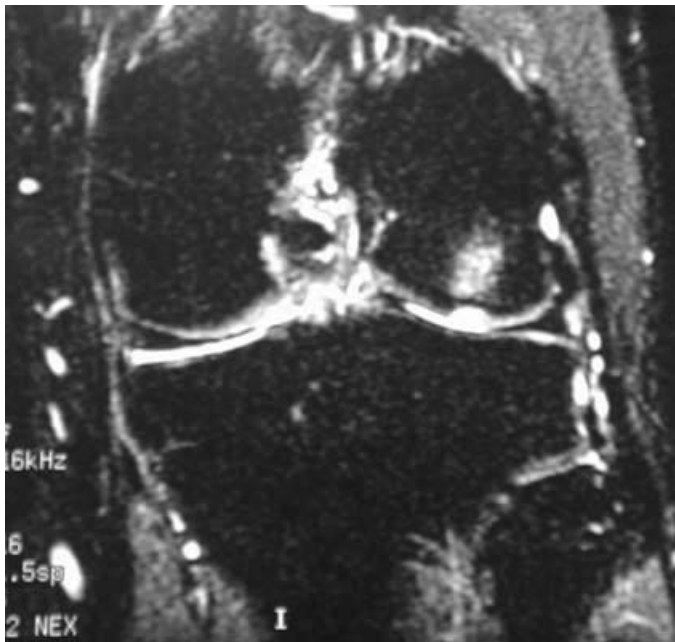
Coronal MRI demonstrates subchondral edema as well as violation of the chondral surface of the lateral femoral condyle.
